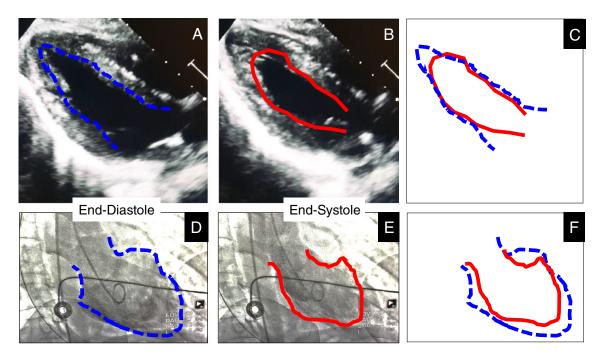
Ventriculographic and echocardiographic assessment of cardiac function obtained at the time of admission. Transthoracic echocardiogram (A and B; parasternal long-axis view) and left ventricular contrast angiography (D and E; right oblique view) show akinesis of the midventricular segments in a noncoronary distribution, as reconstructed in C and F.
